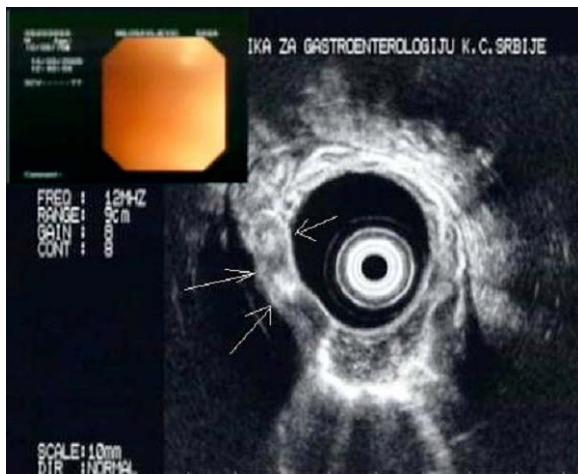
Ultrasound image: T2 tumor of the stomach wall
